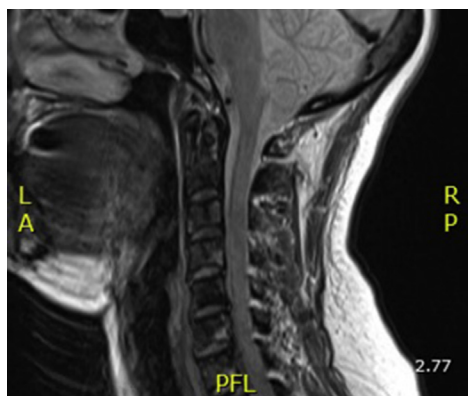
Cervical spine MRI depicts diffuse osseous metastatic disease.
